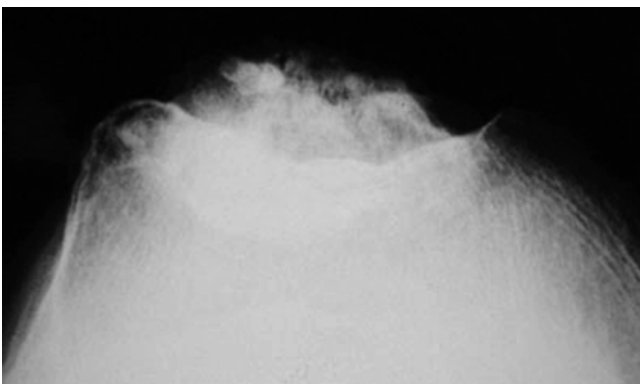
Classical "sunset" sign on the axial radiograph
